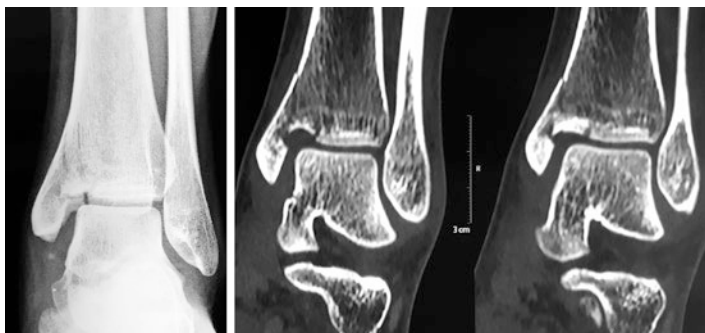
Anteroposterior X-ray post-injury and CT films showing intra-articular step
